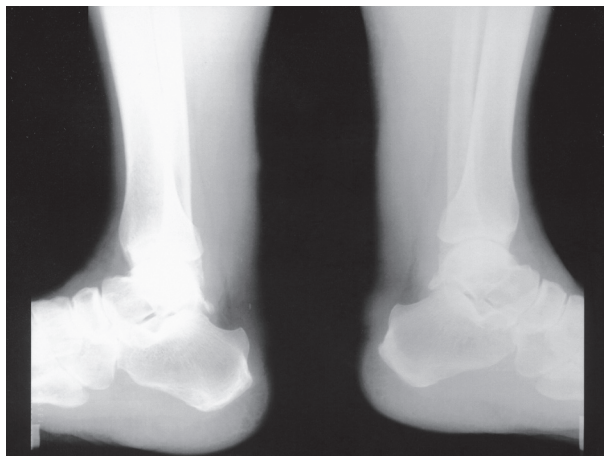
Soft X-rays for the Achilles tendons revealed that the thickness of the right and left Achilles tendons were 21 mm and 23mm, respectively
